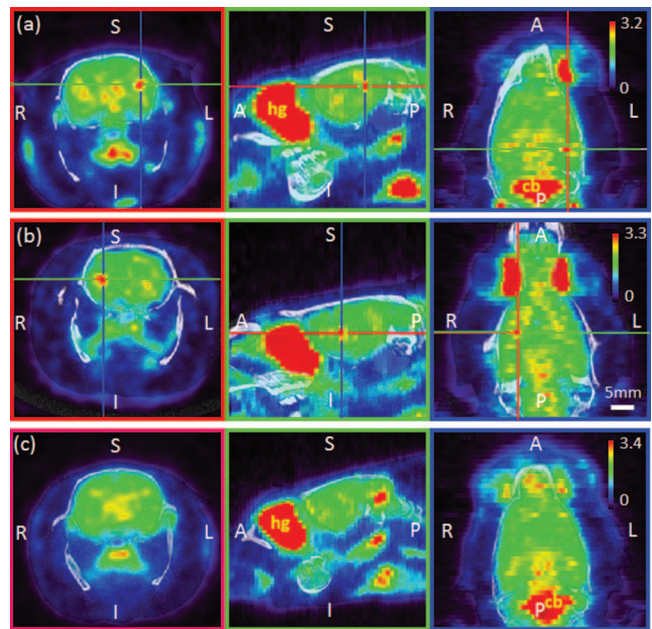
Examples of PET/CT images: Sonication was given on the left (a) or right (b) hemisphere, whereas (c) shows the images from the control condition (i.e., no sonication). The crosshairs in (a) and (b) indicate the location of the center of the acoustic focus. Coronal (first column)/sagittal (second column)/transversal (third column) planes. The vertical bar in the transversal plane indicates pseudocoloring scale of the SUV range. The orientation notations represent the anatomical directions (A: anterior, P: posterior, S: superior, I: inferior, R: right, L: left). Apart from the sonication site, the Harderian gland (hg) and cerebellum (cb) showed relatively higher FDG uptake. The horizontal bar indicates the mm scale, which applies to all images.
